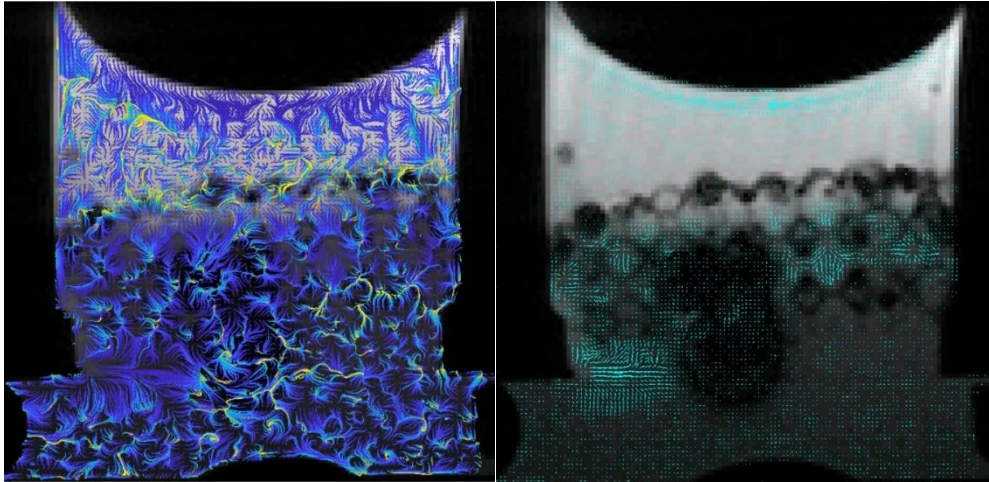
2D MRI image slices overlaid with velocity streamlines (left) and direction streamlines (right) within a IsoTruss scaffold undergoing diffusion flow (infusion rate of 500 $\mu\text{L}/\text{min}$)
